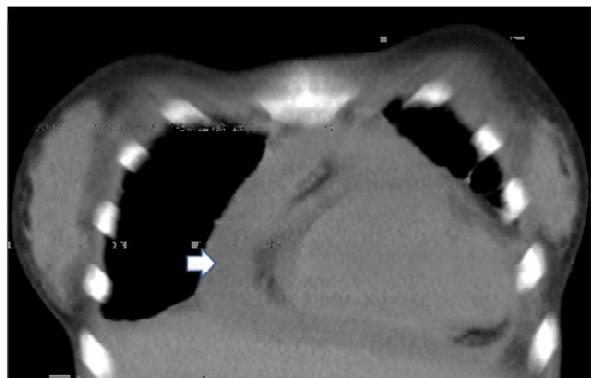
CT chest (coronal reformatted image) showing pericardial effusion (arrows)
